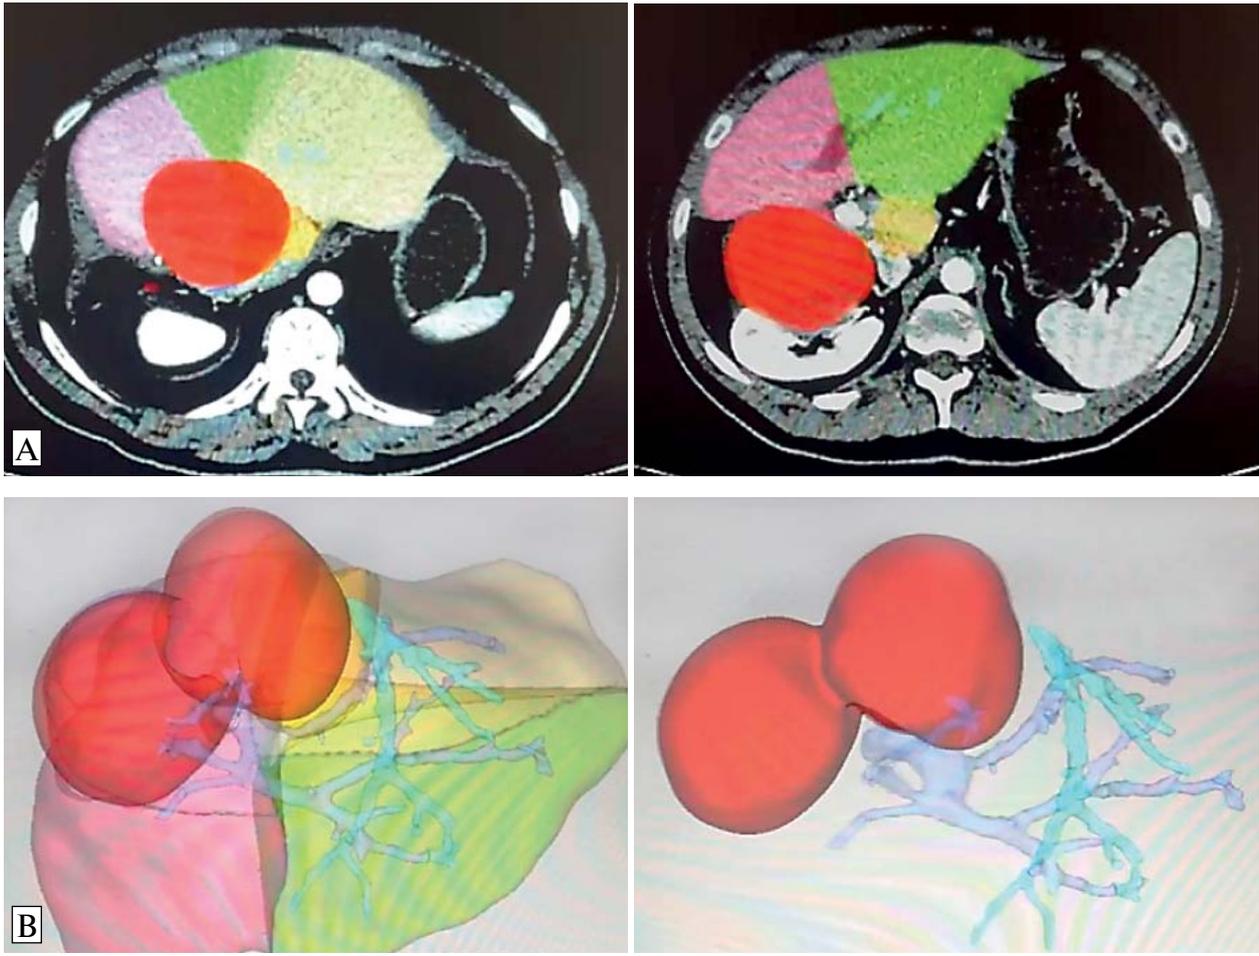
CT volumetry (A) and liver segmentation (B)
